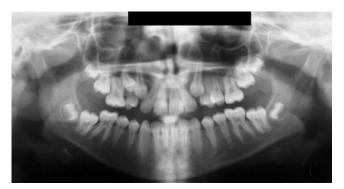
Case report 1: pre-treatment panoral radiograph
